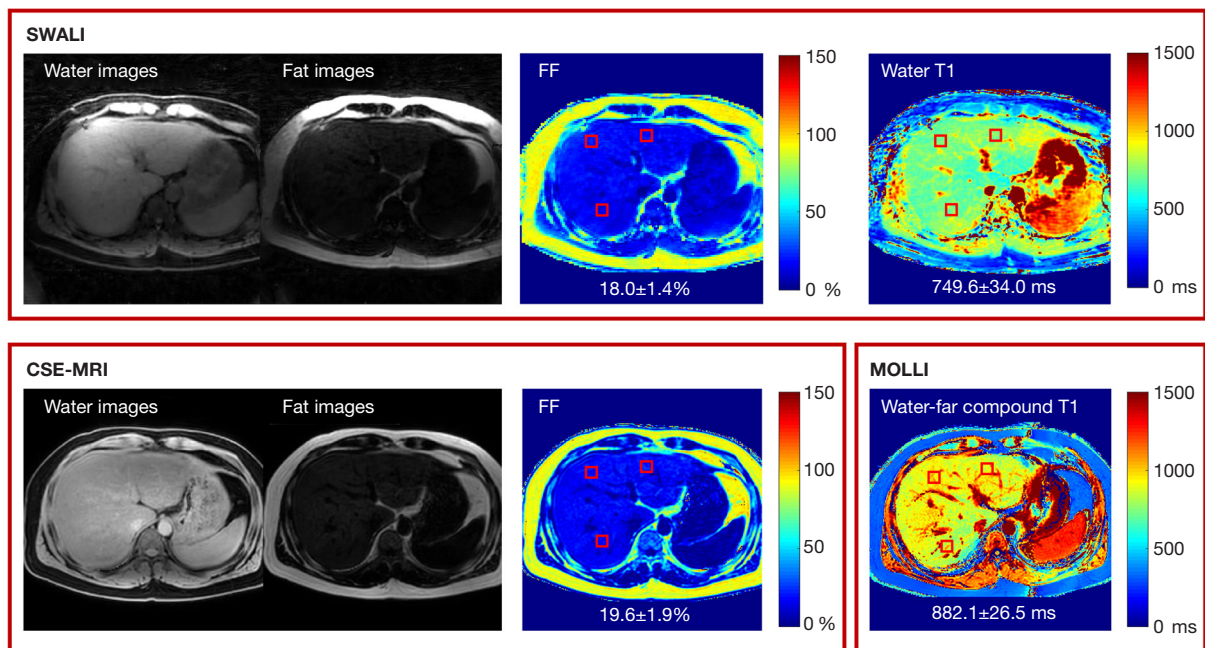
Quantitative mapping results of 1 patient (male, 28 years old) with fatty liver. The separated water image, fat image, FF map, and water T1 map estimated using the proposed SWALI sequence compared with the separated water image, fat image, and FF map estimated using the CSE-MRI sequence and the water-fat compound T1 estimated using the MOLLl sequence. The red squares show 3 ROIs ($\sim 100 \text{ mm}^2$ each) that were manually drawn. The mean FF and water T1 were calculated within each ROI. SWALI, simultaneous water-fat separation and T1 mapping of the whole liver; FF, fat fraction; CSE-MRI, chemical shift-encoded magnetic resonance imaging; MOLLl, modified Look-Locker inversion recovery; ROI, region of interest.
